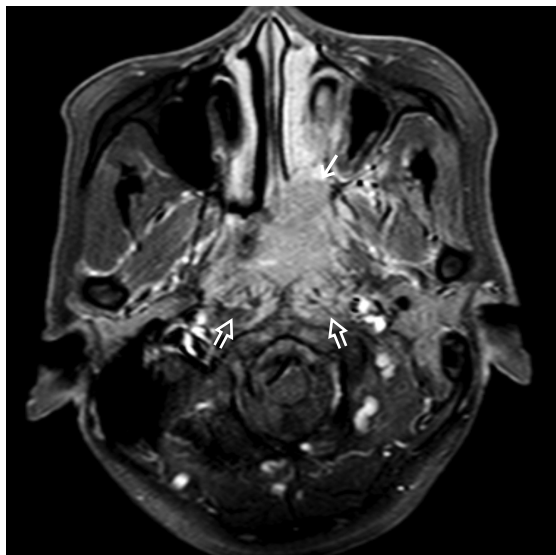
Axial Post-Gd T1 WFS MRI shows large nasopharyngeal carcinoma extending anteriorly to the left posterior nasal cavity (→) and posteriorly to invade bilateral prevertebral muscles (⇨).
